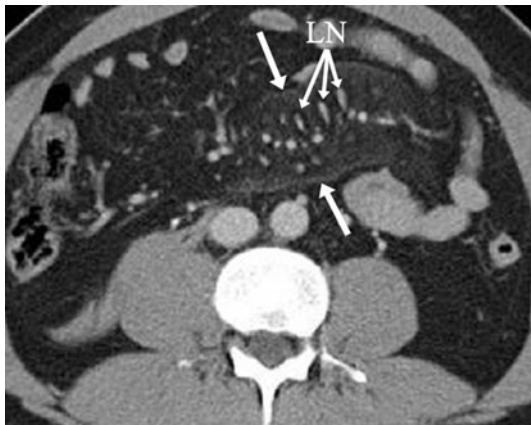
A 37-year-old male status post-blunt abdominal trauma. Axial contrast-enhanced CT of the abdomen demonstrated well-defined fat stranding (arrows), and flat lymph nodes (*LN*) in the mesentery. Chart review revealed that the patient did not have bowel and/or mesenteric injury. CT findings are consistent with mesenteric panniculitis.
